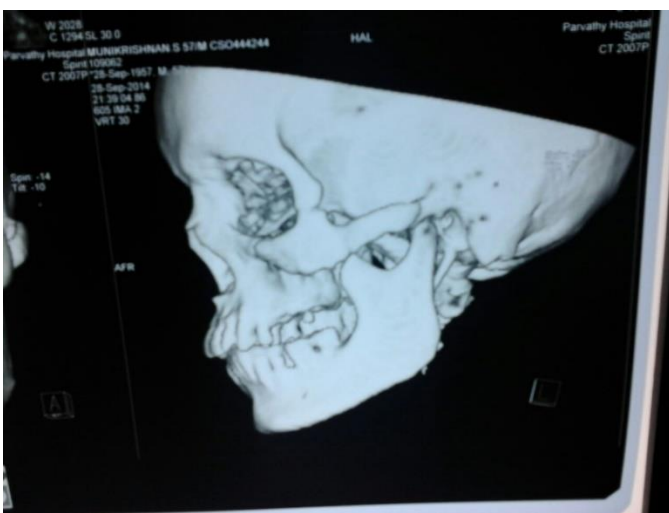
CBCT reveals fracture along the zygomatico-maxillary arch.
